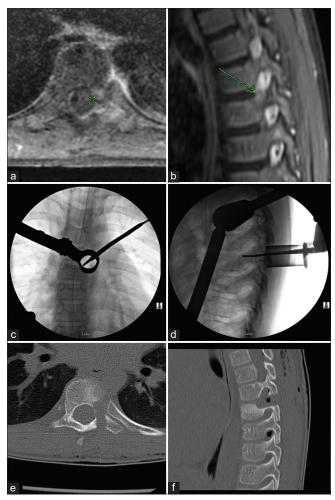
MRI imaging of a T9 lesion with mild contrast enhancement on T1 (a) and hyperintensity on T2 (b) located in the left T9 pedicle (green arrow). Intraoperative fluoroscopy demonstrating tubular retractor location centered overlying the left T9 pedicle (c and d). Postoperative CT demonstrating resection of the left T9 pedicle and 54 partial T8/9 facetectomy (e and f).
